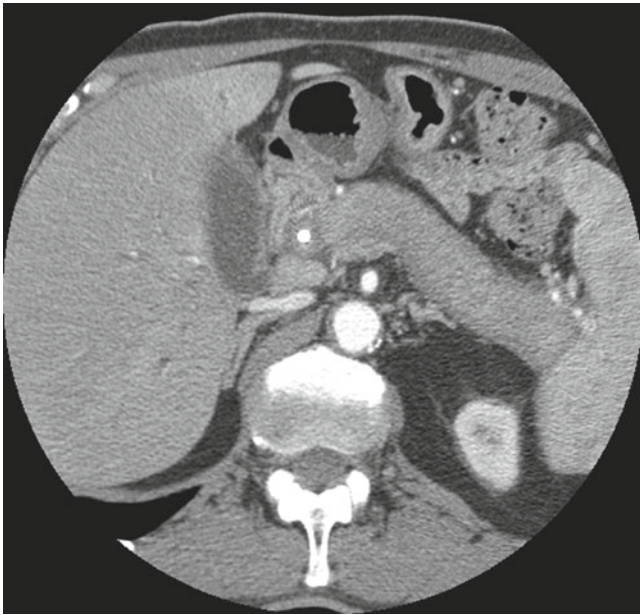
Contrast-enhanced high resolution CT scan in a patient with autoimmune pancreatitis shows a diffusely enlarged gland with a rim like enhancement. This patient also had biliary involvement and underwent stent placement which is evident in this image
